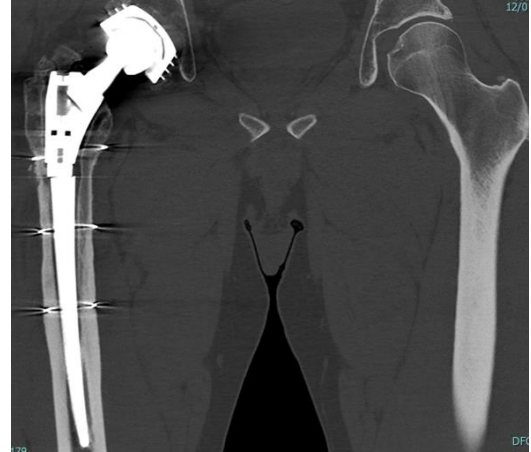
Preliminary CT-scan (coronal) of the second prosthetic modular stem fracture (2023)
